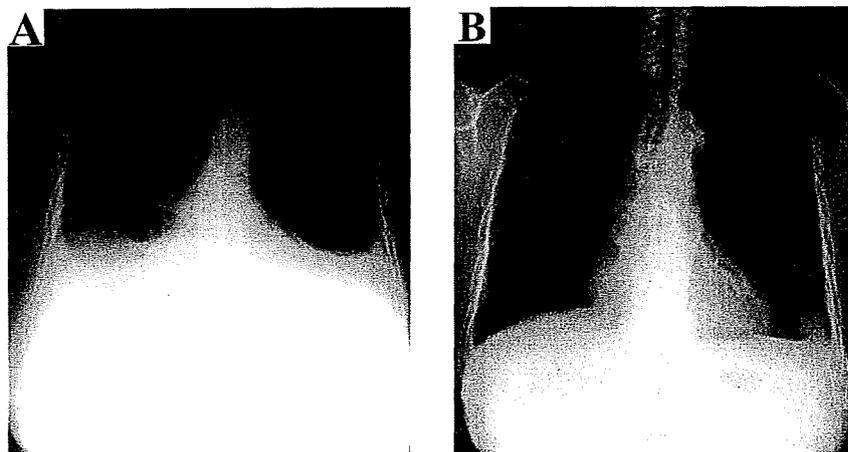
Posteroanterior chest roentgenogram. A, in August 2000, demonstrating massive bilateral pleural effusions. B, in April 2001, demonstrating resolution of pleural effusions.
